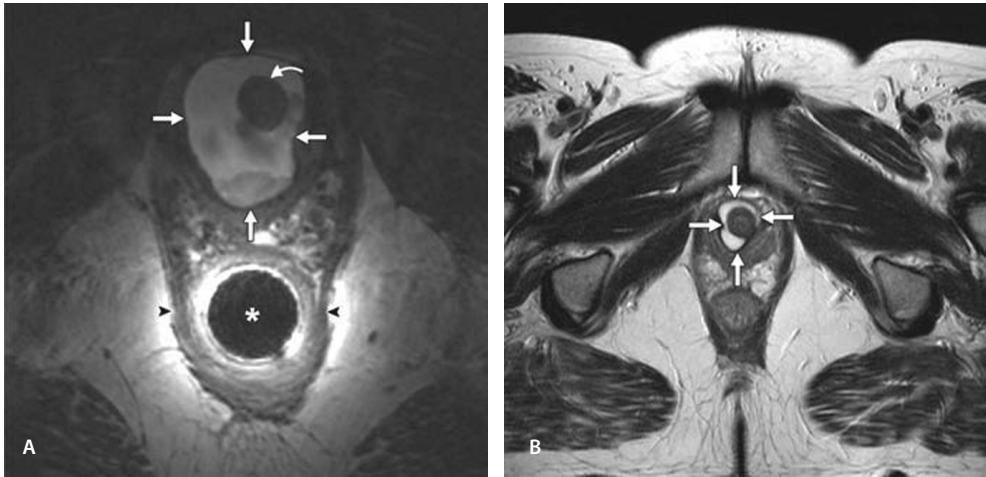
42-year-old-woman with circumferential urethral diverticulum. A, Axial T2-weighted image shows sharp borders (straight arrows) of urethral diverticulum with high inhomogeneous signal intensity containing debris on dependent side. Endoluminal coil (asterisk) is placed in anal canal. Curved arrow indicates urethra, and arrowheads indicate puborectal muscles. B, Axial T2-weighted image acquired almost 1.5 years after surgery shows recurrent or residual urethral diverticulum (arrows). Image was acquired with four-channel phased-array pelvic coil. For optimal imaging results of urethral diverticula, smaller FOV is recommended (see also Figure 5).
